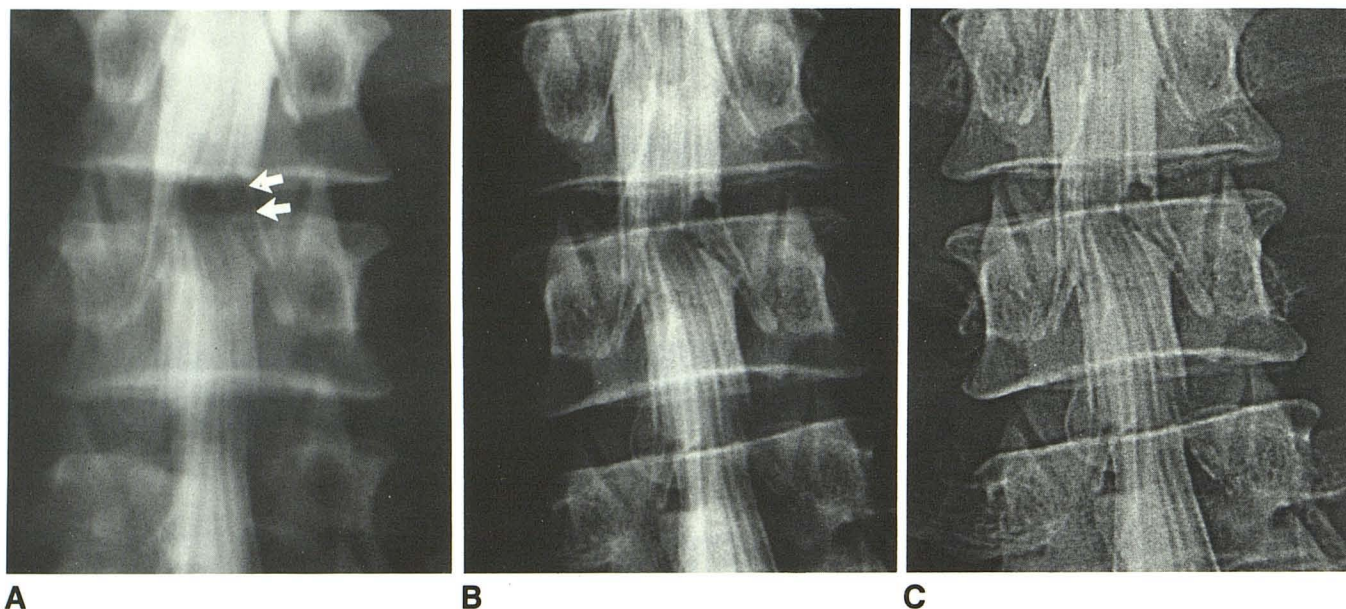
A, Film-screen lumbar myelography shows defect from right-sided intradural herniated disk at L4–L5 level (arrows). B, Computed radiography image of same case. C, Frequency-modified (edge-enhanced) image of same case.
